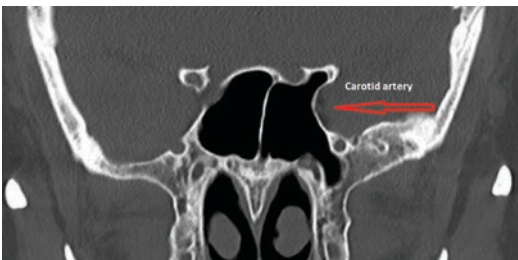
CT scan coronal section showing the carotid artery relation to the lateral wall
